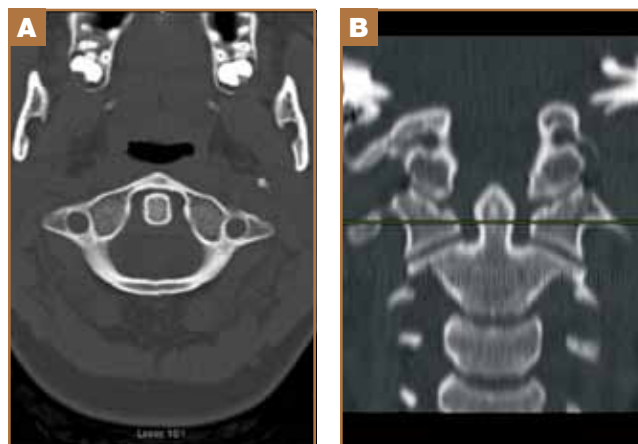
Imaging findings at 6-month follow-up. (A) Axial CT scan showing reduced C1/C2 rotatory subluxation with anatomical alignment. (B) Coronal CT reconstruction showing reduced subluxation of C1/C2 with anatomical alignment.
